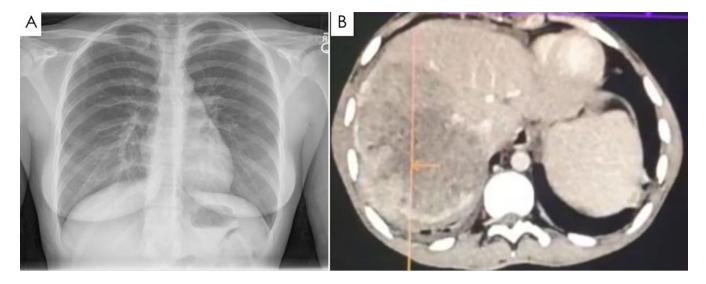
Radiological images of the patient. A. Chest X-ray of patient with absence of any lung metastasis. B. Triple phase contrast-enhanced computed tomography of the abdomen having large space occupying lesion (arrow) in liver suggestive of hepatocellular carcinoma.
